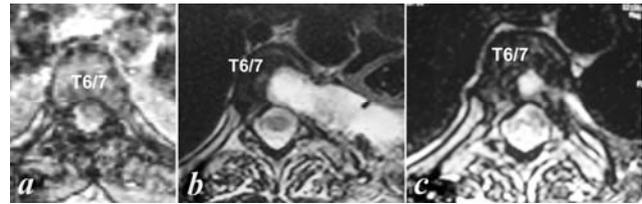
Axial MRI of the thoracic spine. a – preoperative axial MRI at T6-7 shows massive disc herniation compressing the anterolateral surface of the spinal cord; b – postoperative MRI shows a channel created by excision of T6-7 disc and vertebral bodies; c – 1 year after the operation. T6-7 lesion was adequately removed. Post-operative resection channel shows prominent osseous regeneration.
